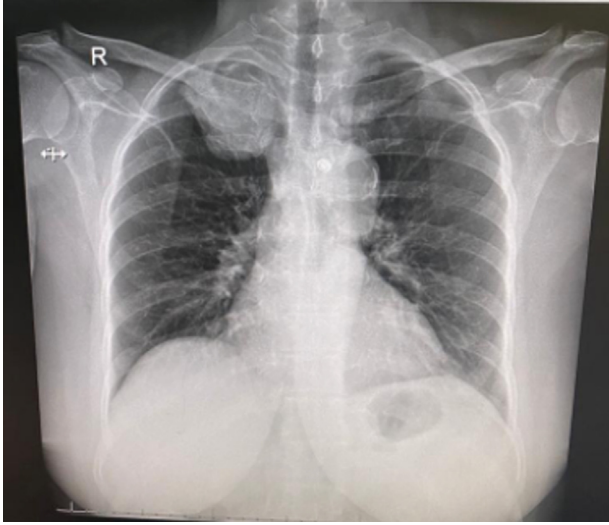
Chest X-ray showing a large expansile lesion involving the third rib on the right side.
